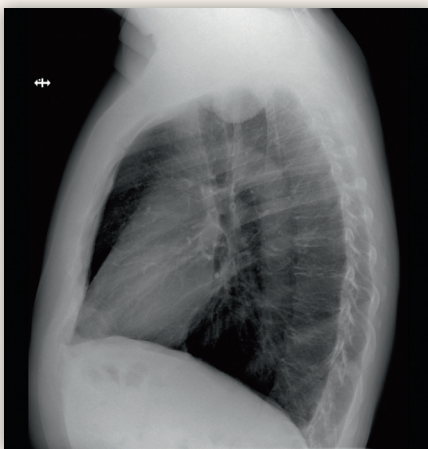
Lateral view chest X-ray in which the apical tumor mass is partially obscured by the shoulder muscles .
